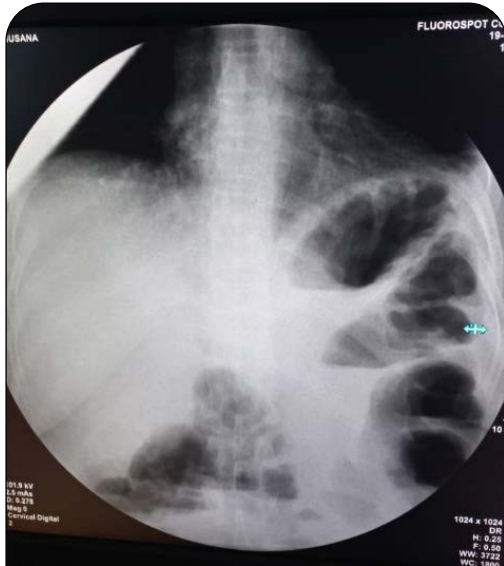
Standing abdominal X-ray where hydro-aerial levels and colonic dilation of the left side can be observed.
